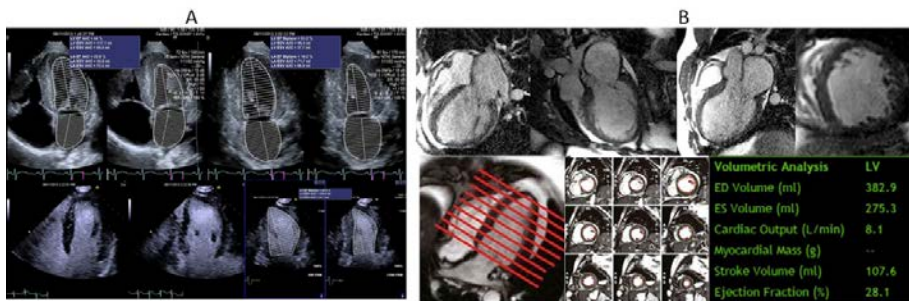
(A) The upper panel shows standard 2-D echocardiographic methods with and without contrast; (B) Left ventricular volumes and LVEF measured using CMR. In about 30% of patients undergoing echocardiography for heart failure, contrast is useful to salvage suboptimal images to allow measurement of LVEF. CMR is not limited by acoustic windows and is a better method when accurate and reproducible measurements of LVEF are necessary.
